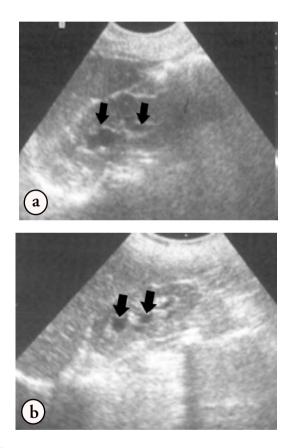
Preoperative renal ultrasound images of the patient demonstrating severe hydronephrosis in the a) left and the b) right kidneys.
